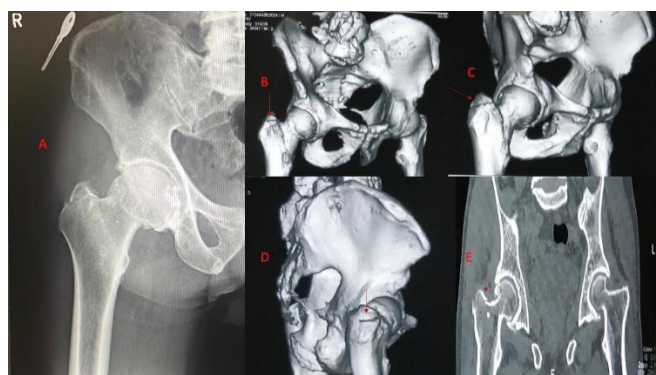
A): Image depicts the isolated minimally displaced GT fracture. B, C, D & E): Images depict the CT images of the fracture showing no extension into the intertrochanteric region
